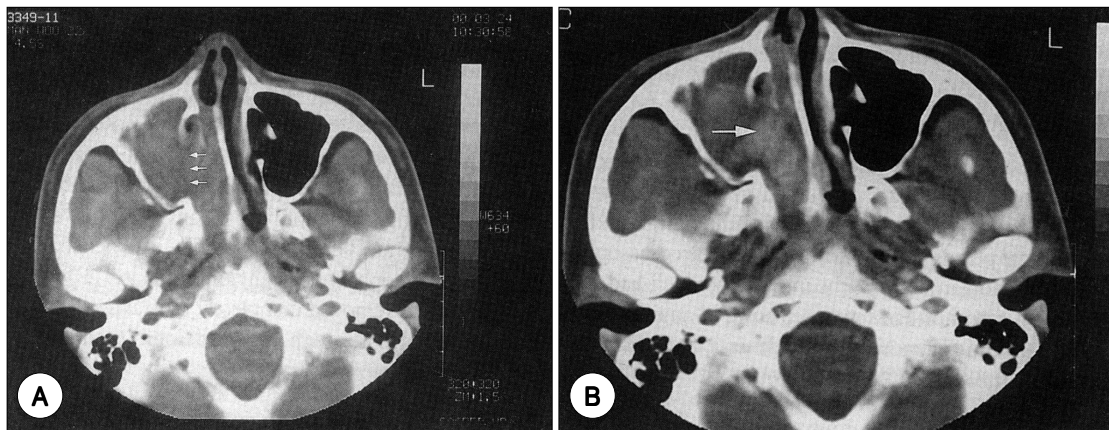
Axial CT scan. A. plane CT scan shows a soft tissue mass involving the right maxillary sinus and nasal cavity and severely obliterated medial wall of the right maxillary sinus (small arrow). B. contrast CT scan shows inhomogeneous enhancing mass (large arrow).
